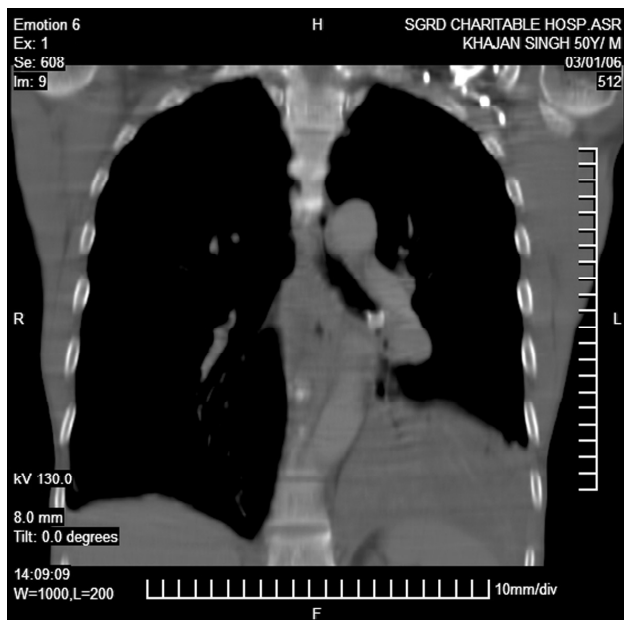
Findings of Fig. 1 in coronal CT image.
